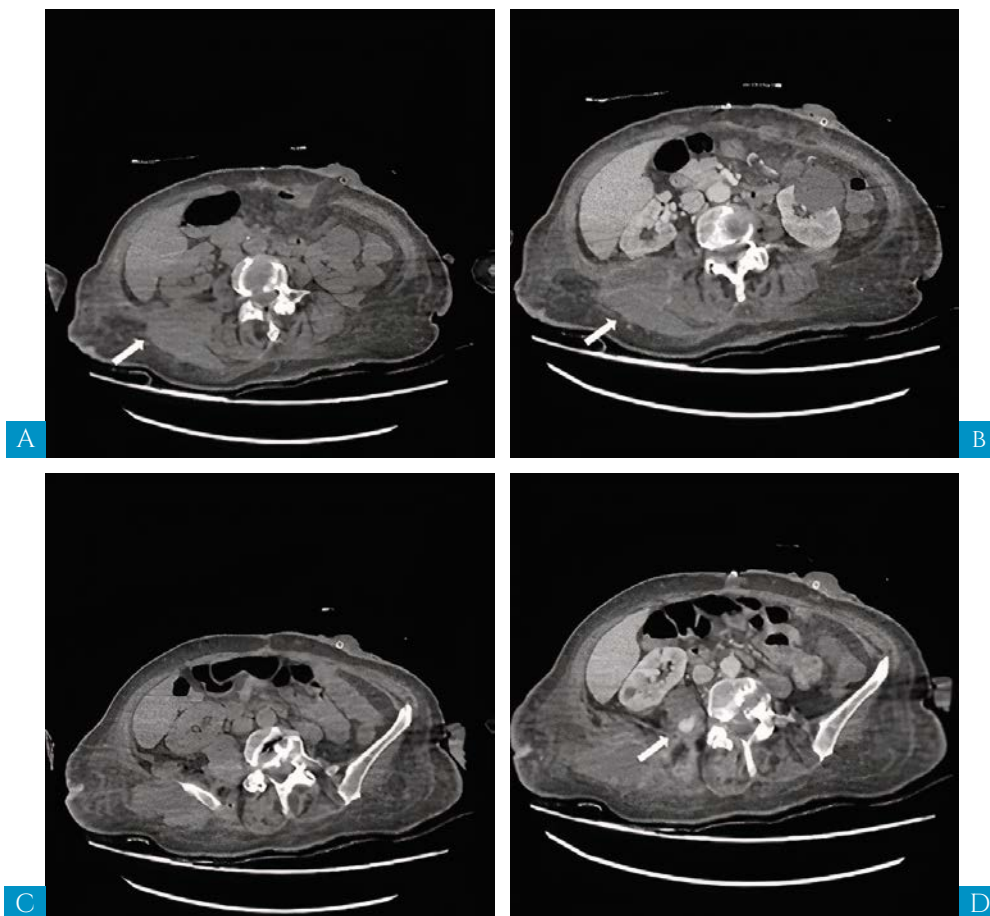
a, b, c, d: pre contrast and post contrast abdominal CT revealed the multiple collections in the retroperitoneal cavity and subcutaneous tissue, some of which were also clinically visible. However, an incidental finding was seen in the post contrast CT; a round, well circumscribed lesion of contrast attenuation in the right psoas muscle collection, corresponding to an aneurysm of the L4 lumbar artery.
